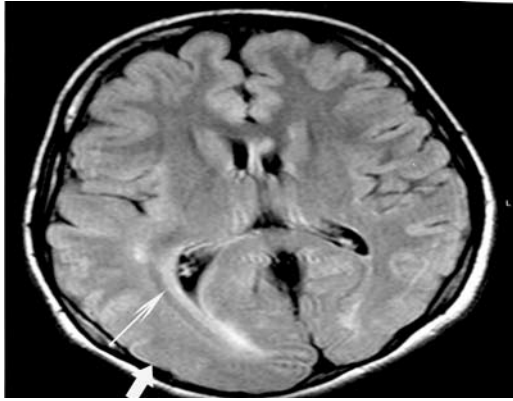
Magnetic resonance imaging transverse FLAIR image at the level of the lateral ventricles shows hemimegalencephaly on the right side with mild pachygyria posterior temporal and occipital cortex (thick arrow) and periventricular band heterotopia (thin arrow).
